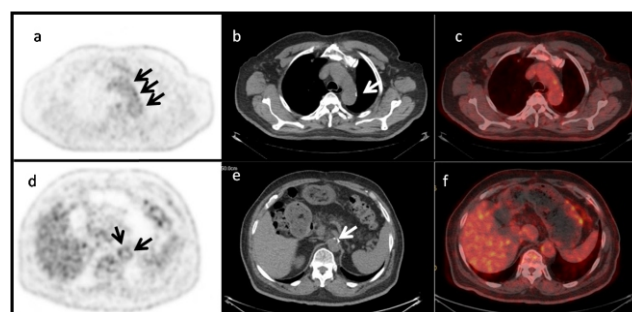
A 72 years old man with IDDM who underwent ^{18}F -FDG PET/CT imaging. PET images (a, d) and fusion PET/CT images (c, f) show increased ^{18}F -FDG uptake (black arrows) in walls of aortic arch and abdominal aorta due to atherosclerotic inflammation. Macroscopic atherosclerotic calcification (white arrows) in walls of aortic arch and abdominal aorta was also visually detected using axial low-dose CT images (b, e). SUVmax and SUVmean were 2.9 and 2.2 for aortic arch, and 2.6 and 2.4 for abdominal aorta, respectively.
